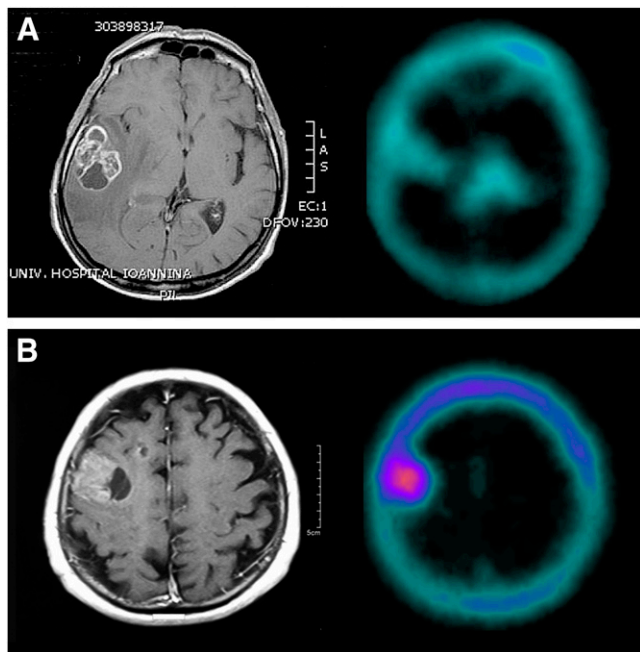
Contrast-enhanced T1-weighted MR image (left) and ^{99m}Tc -tetrofosmin SPECT image (right) in one GBM patient exhibiting low tracer uptake (A) and in another with high uptake (B) (patients 6 and 18 from Table 1, respectively).
